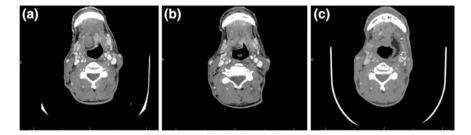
Computed tomography (CT) neck with contrast of deeply infiltrative recurrent left base of tongue oropharyngeal squamous cell carcinoma (OPSCC) before (a) and after (b) neoadjuvant chemotherapy followed by a hybrid transoral robotic surgery (TORS)-assisted approach with microvascular free flap reconstruction (c)
